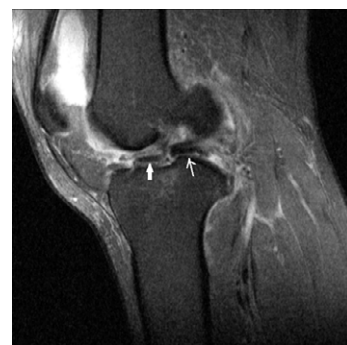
Sagittal T2-weighted MR image through the intercondylar notch shows displaced bucket-handle fragments of both medial (thin white arrow) and lateral (thick white arrow) meniscal tears like two consecutive silkworms
